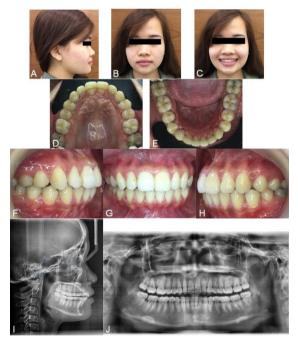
Patient after 14 months of treatment; A) Extraoral profile view; B) Extraoral straight view; C) Smile straight view; D) Maxillary occlusal view; E) Mandibular occlusal view; F) Intraoral right lateral view; G) Intraoral straight view; H) Intraoral left lateral view; I) Cephalometric radiograph; J) Panoramic radiograph
